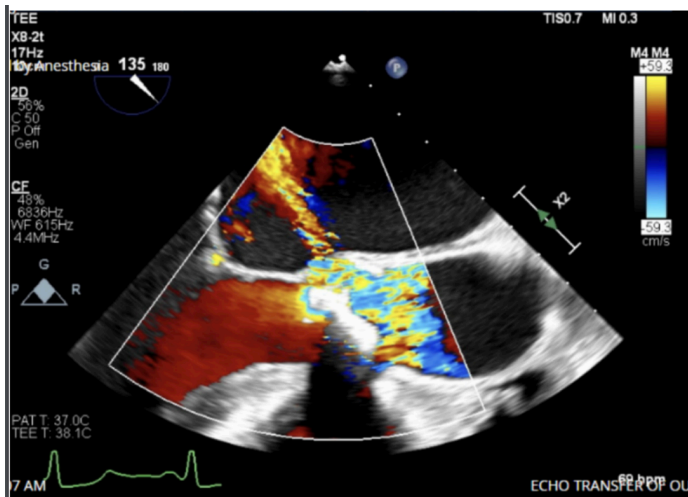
Transesophageal aortic valve long axis view demonstrating high velocity color flow Doppler jet from the aortic root into the left atrium.
